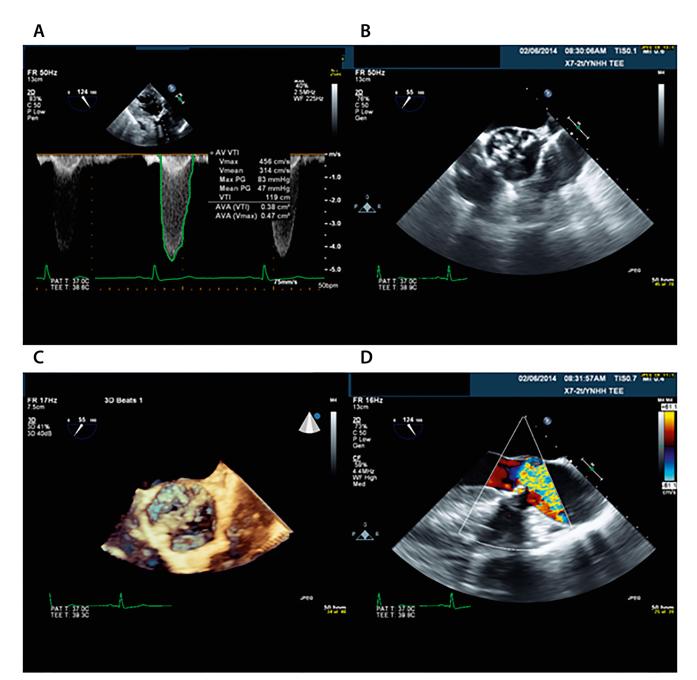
Panel A. Continuous wave Doppler profile from deep transgastric view shows an aortic valve area of 0.47 cm², mean velocity of 314 cm/s, and mean pressure gradient of 47 mm Hg. Trans-esophageal echocardiography (TEE) images of the aortic valve (*Panel B*) from short-axis view and (*Panel C*) from 3D reconstruction of aortic valve. Arrows point to heavy valvular calcification. *Panel D*. Color Doppler profile from long axis view shows highly turbulent flow behind aortic stenosis.
